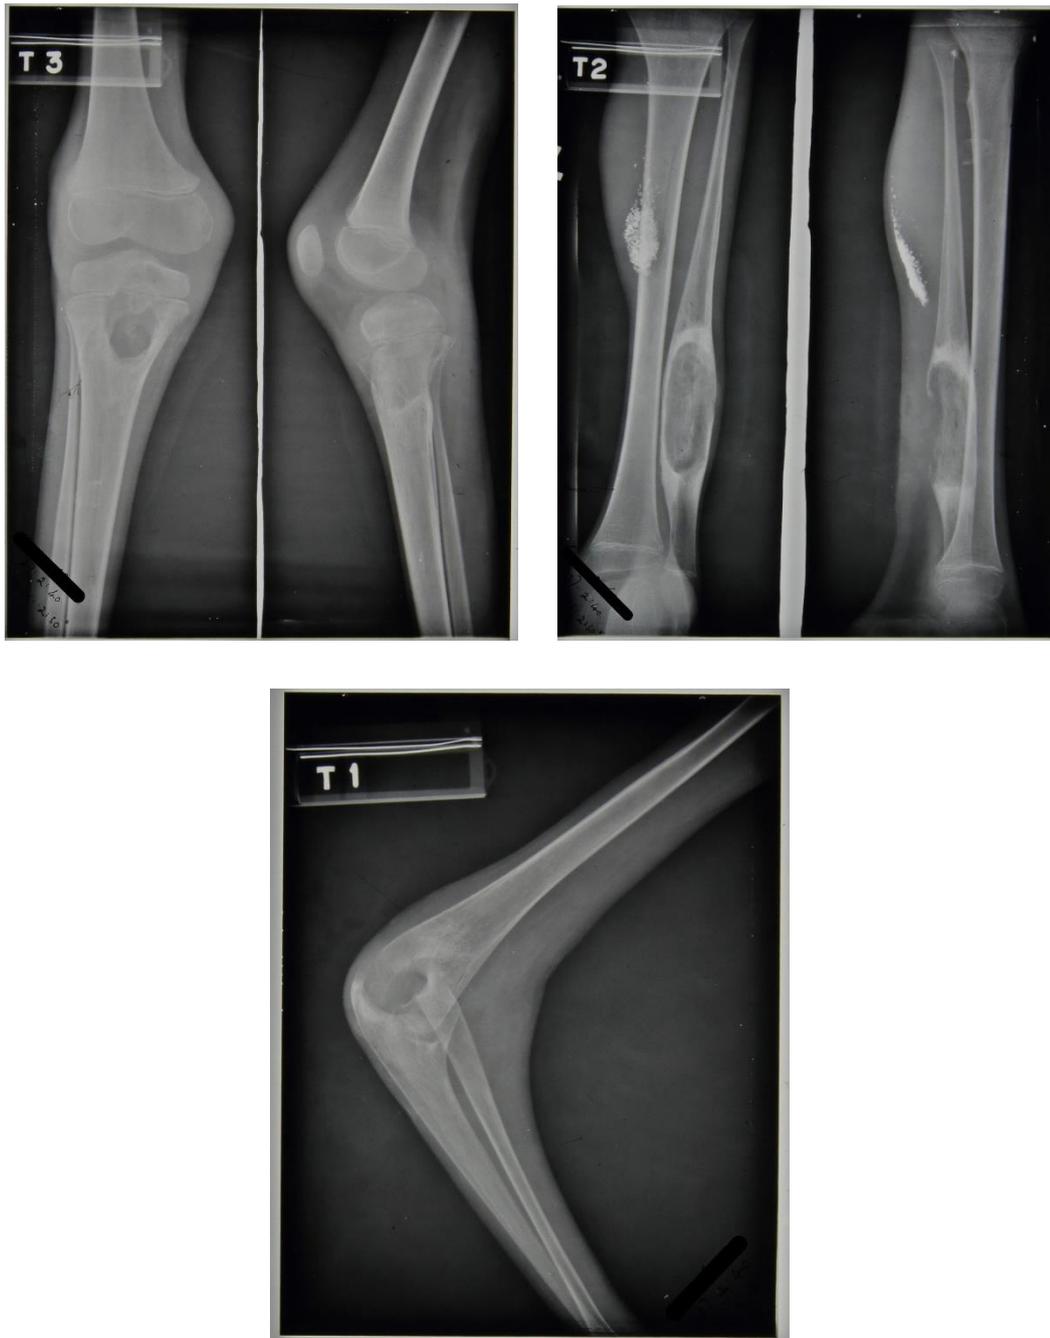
Patient 81/39 radiograph report 27th February 1940 (HOSP/STAN/7/1/2/91_03, 17 & 18)
